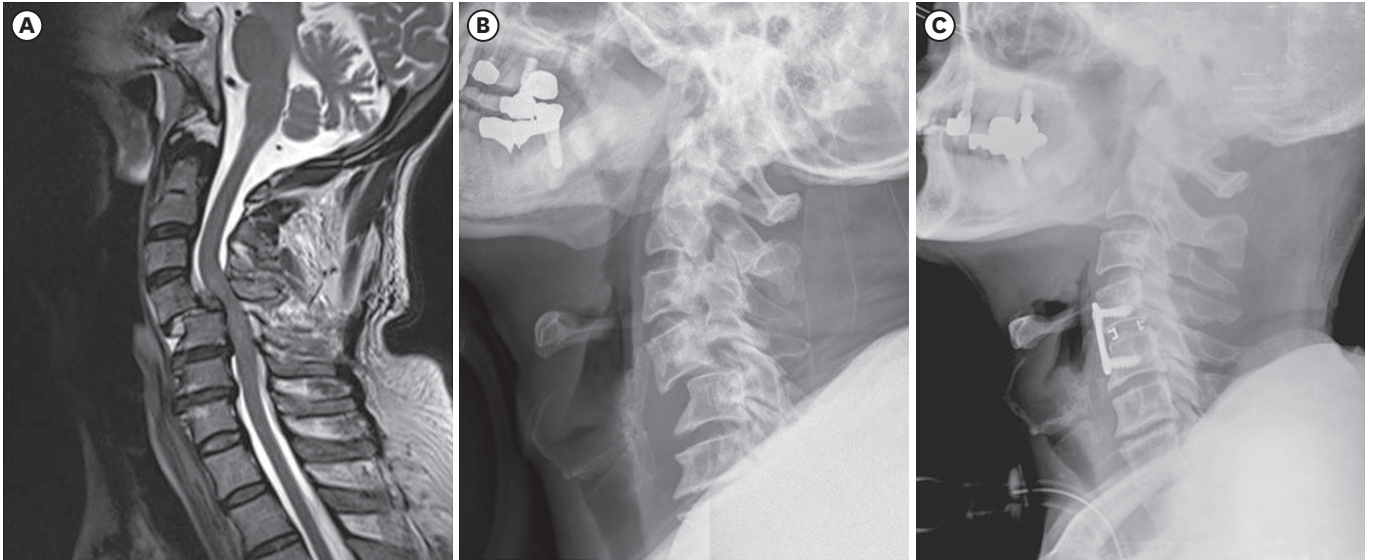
A 42-year-old male with C4-5 facet fracture and dislocation. (A & B) Preoperative T2-weighted cervical sagittal MR imaging and lateral radiograph showing a facet fracture and dislocation at the C4-5 level. (C) Lateral radiograph shows a relatively remote distance between the 2 surgical procedures. MR: magnetic resonance.
